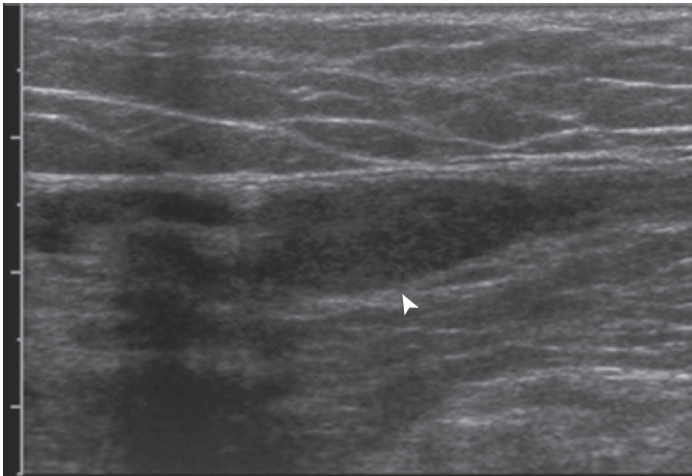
Undescended testis. Ultrasound demonstrates a testis, indicated by the arrowhead, in the inguinal canal. (Image courtesy of Vikram Dogra, MD.)
